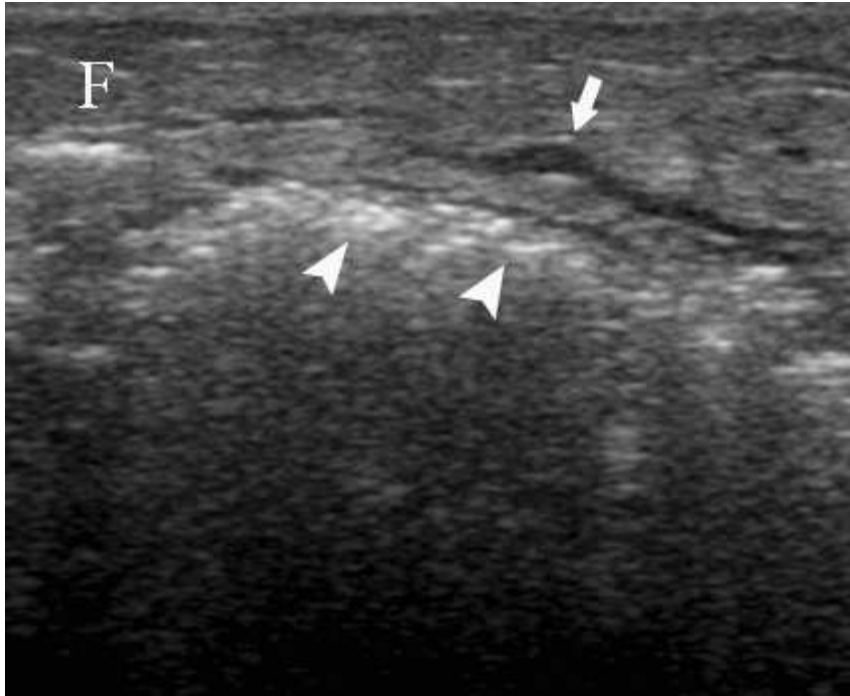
A transverse ultrasound scan of the forearm shows a hyperechoic layer above the deep fascia with posterior acoustic shadowing that corresponds to soft tissue emphysema (arrowheads). The overlying fatty tissue has increased echogenicity with interlacing anechoic spaces (arrow) representing perifascial fluid spreading along the fascial planes (cobblestone appearance). F – fatty tissue.
